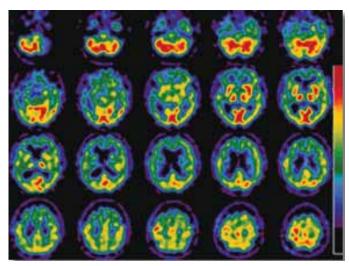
PET CT Scan of Vascular Dementia
